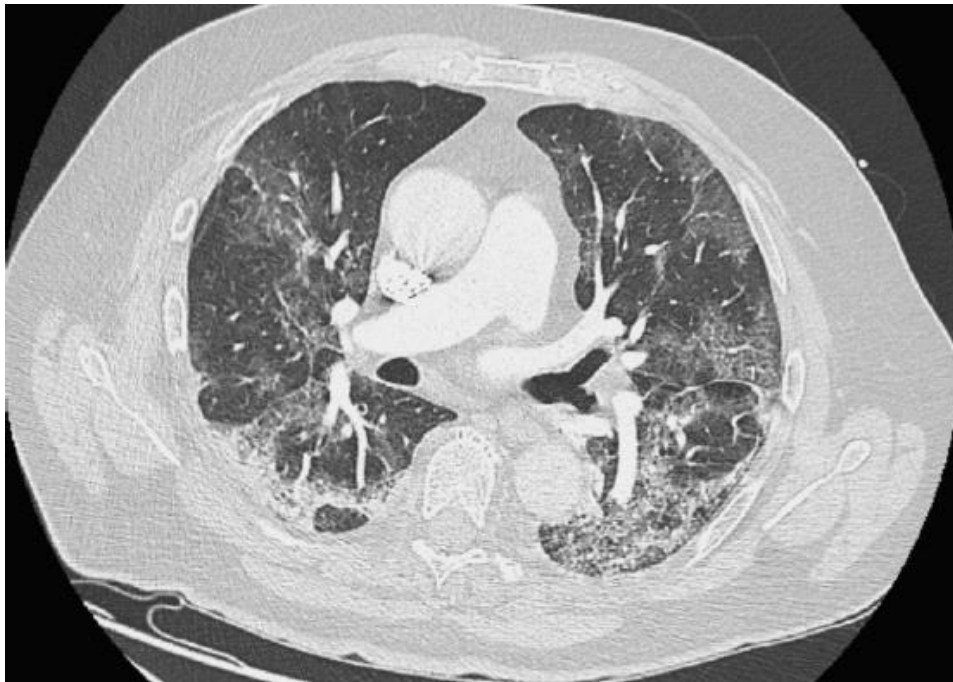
CT scan showing bilateral, multilobar ground glass opacities and crazy-paving consolidation without evidence of both pulmonary embolism and pleural effusion.
